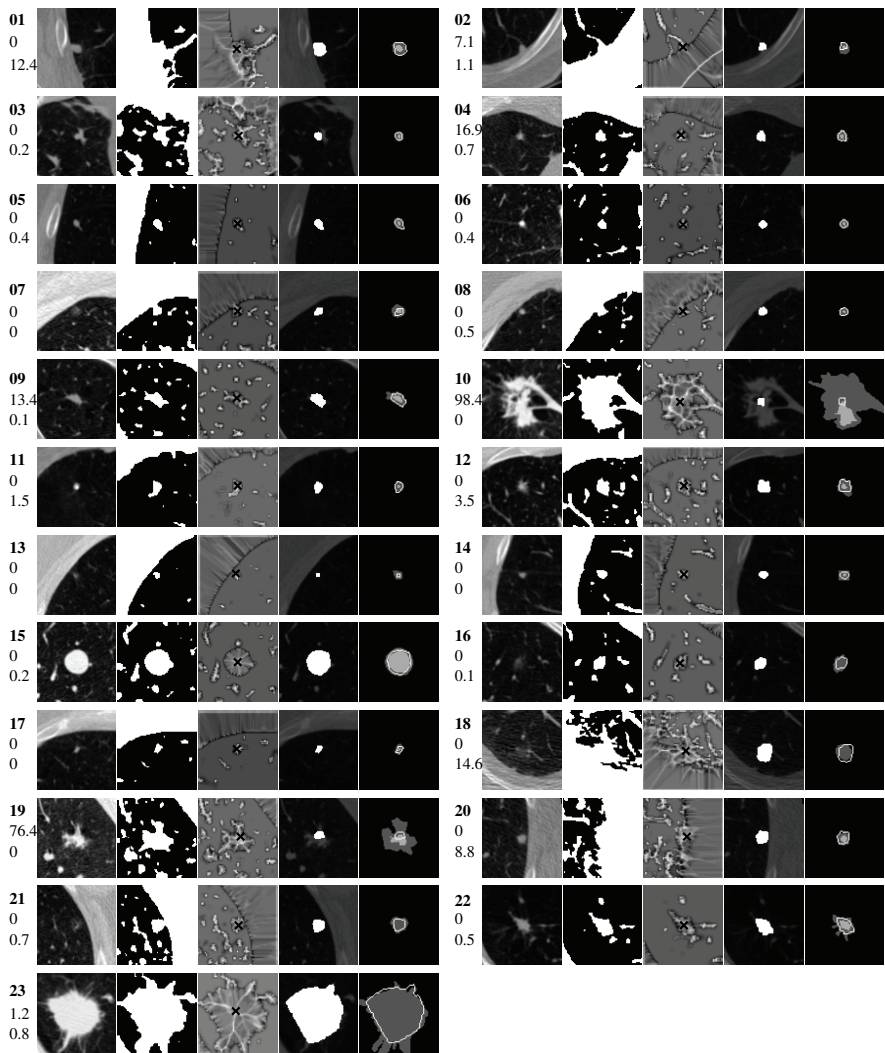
shows results of the figure-ground separation process applied to 23 data sets provided by the NIH Lung Imaging Database Consortium (LIDC)[7]. For each data, five images are shown. The left image is a representative axial slice of the nodule in the original CT data. The second image from the left is the result of the figure-ground separation. The other three images are results of seed point localization and segmentation processes, which are discussed in detail below. A bold number accompanying each set of images is a unique number for identifying the data, and two non-bold numbers indicate the accuracy of the segmentation. We will describe the accuracy measures in Section 3. Note that the images are shown at the resolution of the original CT data. Thus, all results shown are interpolated back to the resolution of the original CT data.
